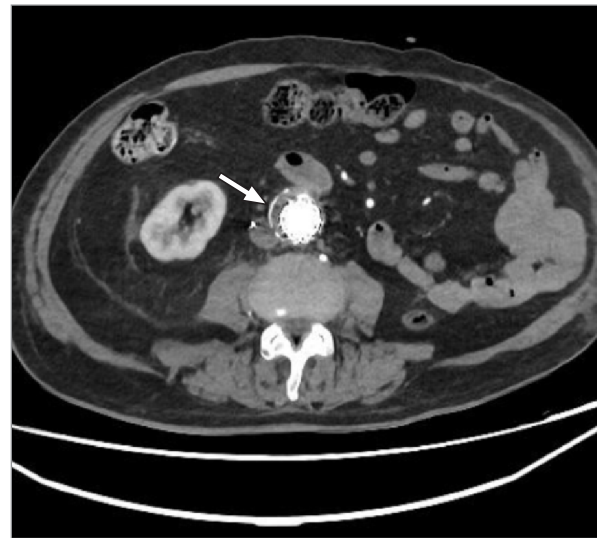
Axial abdominal computed tomogram before hospital discharge demonstrates a thrombus (arrow) outside the Myval prosthesis (Meril Life Sciences Pvt Ltd) at the right lateral abdominal aortic wall located 4 cm from the iliac bifurcation.
